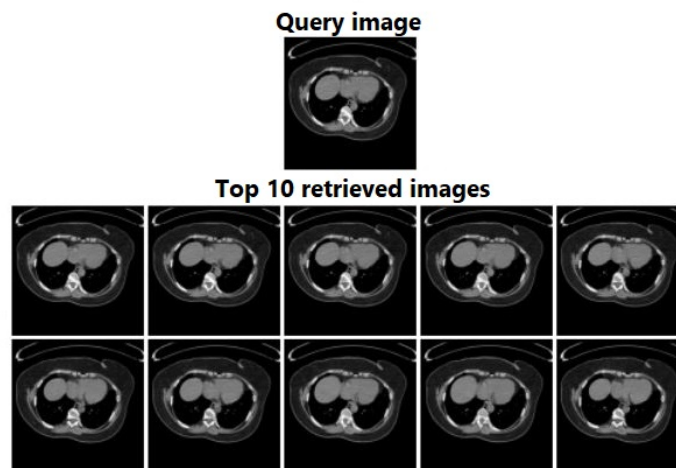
Retrieved images for a TCIA-CT dataset query using RbQE with VGG-19.
